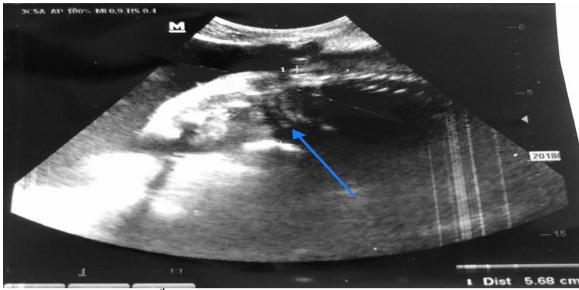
Ultrasound image at 28^{th} weeks of gestation of the uterine defect measuring 5.68 cm through which protrudes the right arm and hemithorax of the fetus.
